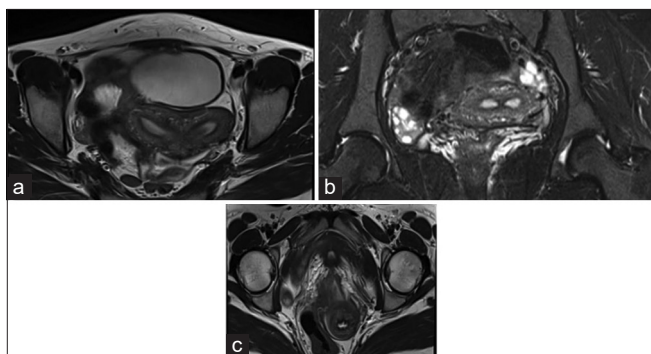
(a) Axial T2-weighted image showing two separate endometrial cavities with increased inter-cornual distance and obtuse angle between the uterine horns s/o Bicornuate uterus. (b) Axial T2-weighted image showing normal bilateral ovaries and separate endometrial cavities as described. (c) Axial T2-weighted image showing a common cervical canal. A common vaginal canal was also noted European Society of Human Reproduction and Embryology in this patient U3BC0V0
